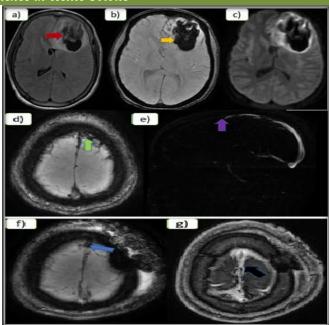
(a-g) showing an intraparenchymal hemorrhage in the left frontal lobe secondary to superior sagittal sinus thrombosis. Fig a)- FLAIR image demonstrating heterogeneously hypo to isointense lesion (Red arrow) in the left frontal lobe with surrounding edema. b & d – SWAN images showing blooming in the affected region (yellow arrow) and in the superior sagittal sinus (green arrow) in its anterior aspect. Fig c – DWI image showing no true diffusion restriction. e- MRV TOF image demonstrating thrombosis (purple arrow) in the anterior half of superior sagittal sinus. Fig f & g – Postoperative mages showing mild reduced thrombosis (blue and black arrow) in the superior sagittal sinus.
